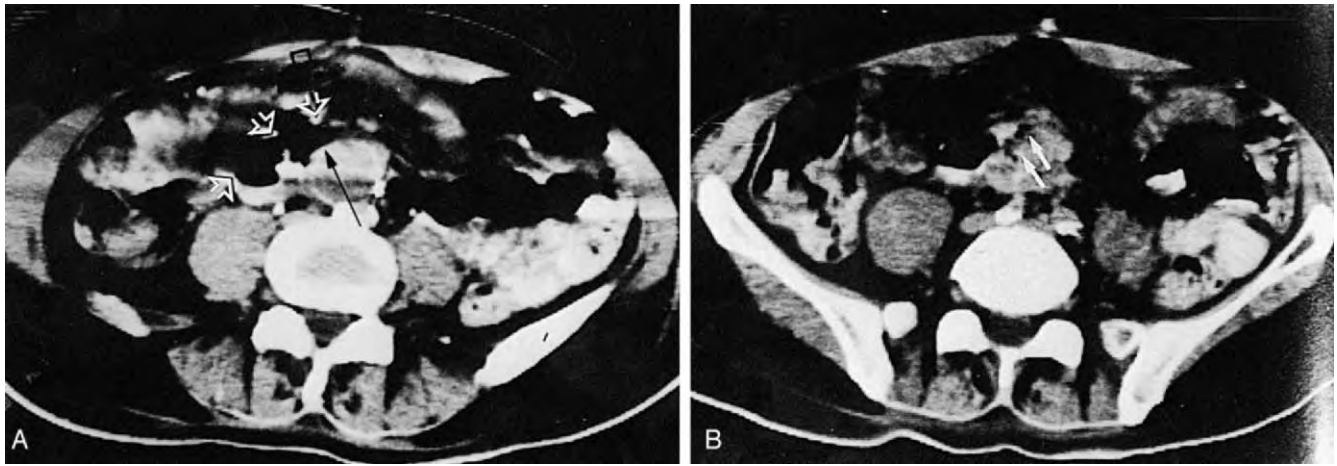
Computed tomographic scan of aortoenteric erosion. A, Apparent erosion of an aortic graft (*black arrow*) into the overlying duodenum (*open arrows*). B, Perigraft air (*arrows*). (From Bernhard VM: Aortoenteric fistulas. In Rutherford RB [ed]: Vascular Surgery. Philadelphia, WB Saunders, 1989, p 530.)
